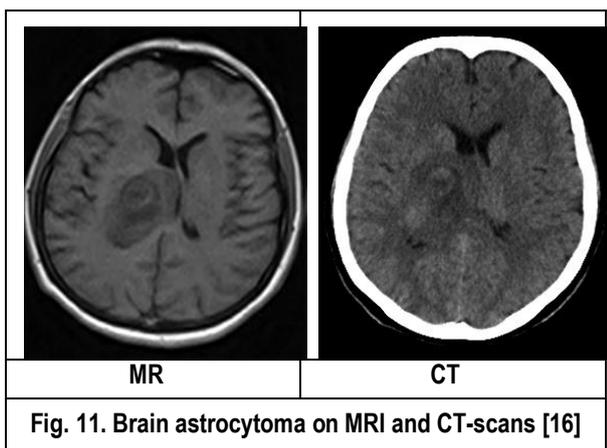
Brain astrocytoma on MRI and CT-scans [16]
